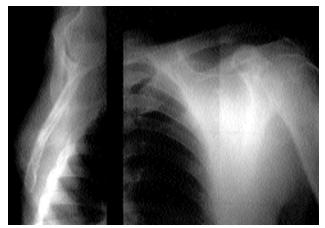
Radiography, Ewing sarcoma in scapula
